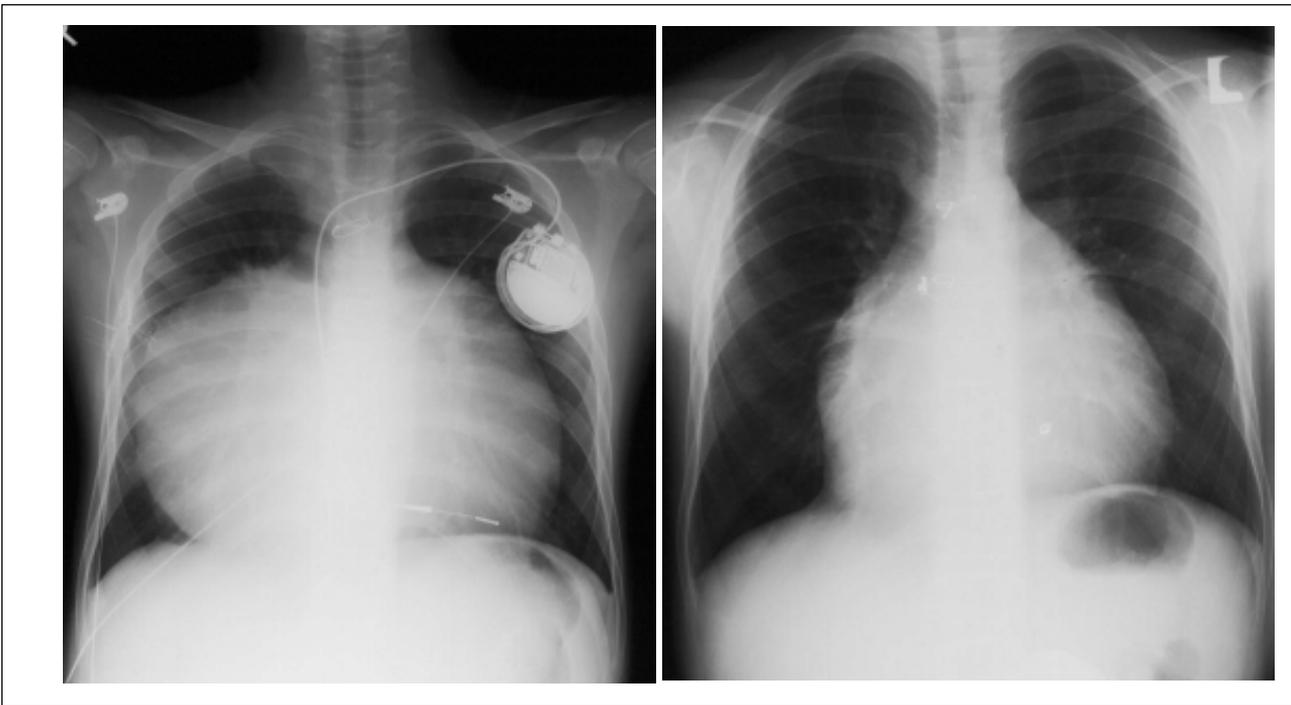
Gross cardiomegaly (cardiothoracic ratio 0.88) on the chest radiography before homograft operation, reduction of cardiothoracic ratio to 0.57 after operation. The endocardial leads was removed and two epicardial leads were implanted.
